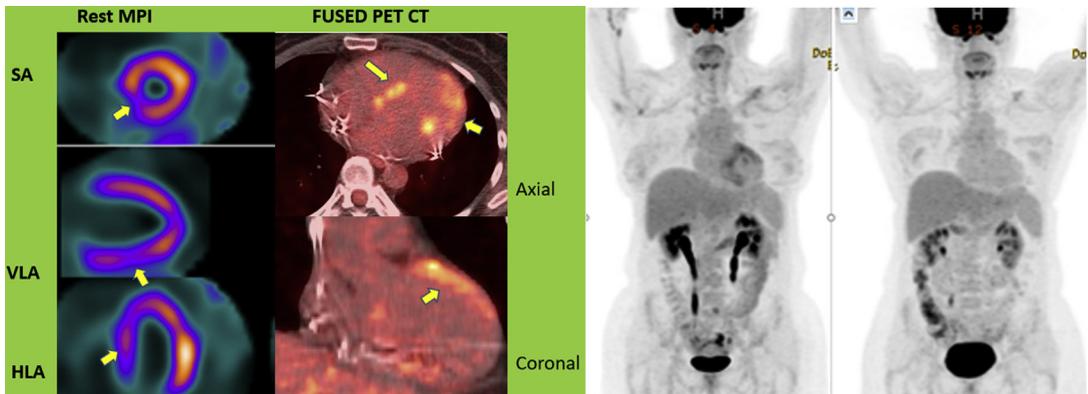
A 54-year-old woman with CS. Rest perfusion images with abnormal perfusion in septum and inferior wall (arrows, left/1st column). Fused FDG PET-CT and MIP images with focal on diffuse uptake, notable in the anterior, inferior, anterolateral, and septal myocardium, consistent with active inflammation (2nd and 3rd column). Follow-up PET CT showing significant improvement after patient placed on steroids and immunosuppression, as shown on MIP images (right/4th column). This patient could not undergo CMR due to an incompatible defibrillator. HLA, horizontal long axis; SA, short axis; VLA, vertical long axis.
